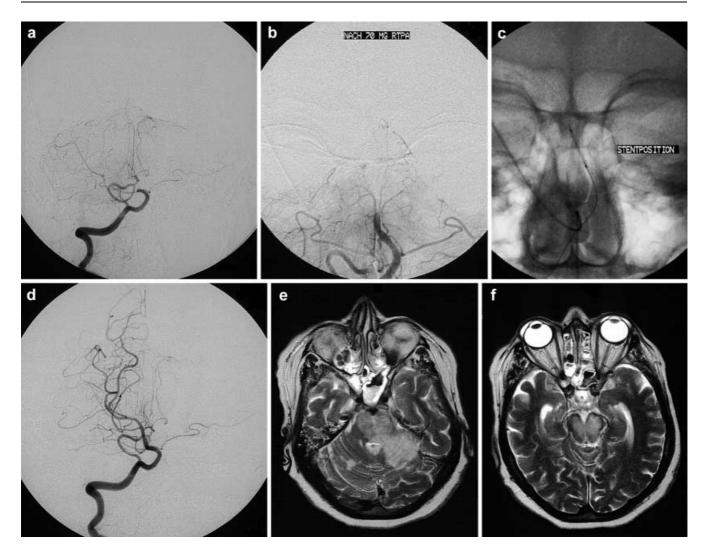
Patient 3. a Occlusion of the middle BA. b Reopening of a short stump of the BA after LIF with 50 mg rt-PA, persisting occlusion of the distal BA. c Positioning of the stent. d Result after stent application. e, f MRI shows extensive infarctions of the pons and mesencephalon (6 days after stroke)
